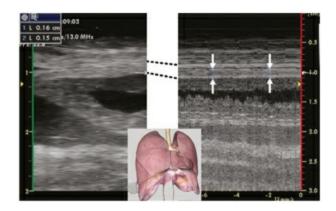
Normal diaphragm thickening. Lung ultrasound 2D and M-mode images obtained using a linear probe in zone 4 shows normal thickening of the diaphragm during respiration.
